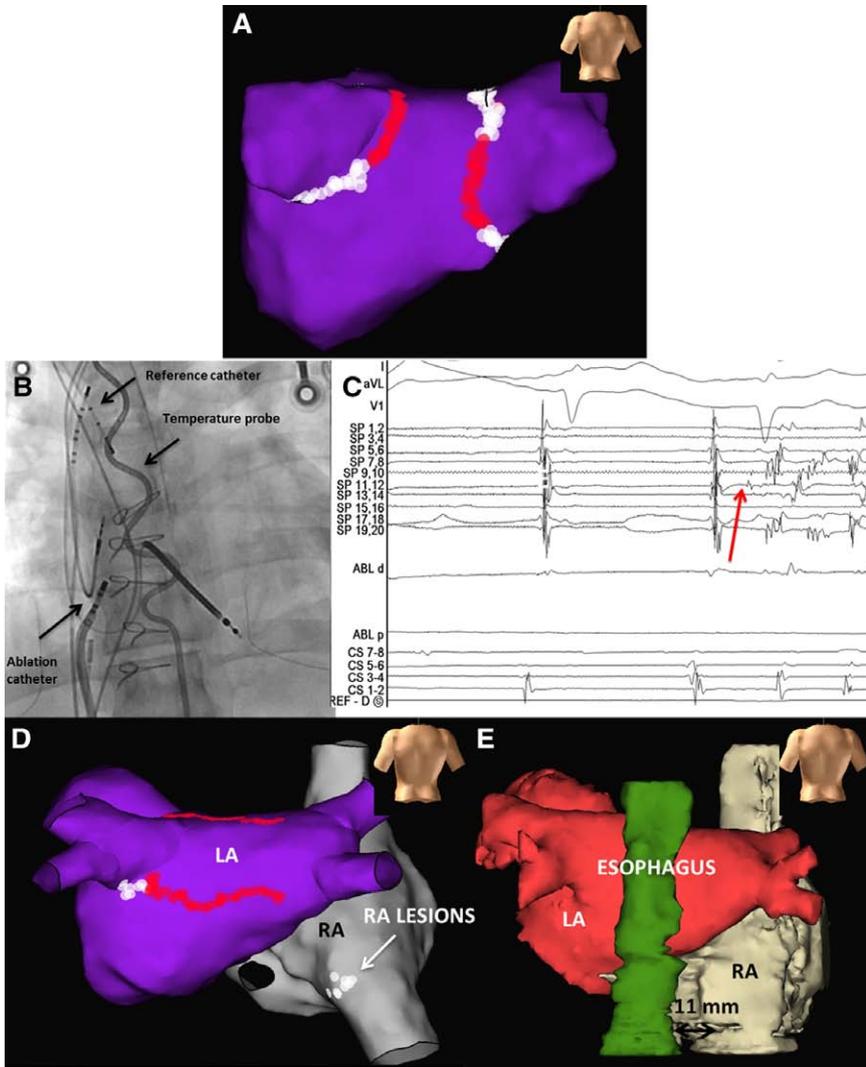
A, Initial pulmonary vein (PV) isolation with esophageal temperature rises (red lesions) seen on posterior wall. B, Fluoroscopic (anteroposterior) view of ablation catheter at site of triggering atrial premature complexes, with respect to the esophageal temperature probe. C, Intracardiac electrogram of atrial fibrillation trigger demonstrated on multipolar mapping catheter (spiral [SP] 11, 12). D, 3-Dimensional map of right atrium (RA), left atrium (LA), and ablation lesions (posterioranterior view). Extension of PV isolation with posterior wall isolation (esophageal temperature rise at red lesions). E, Relationships between RA, LA, and the esophagus (PA view) of CT reconstruction.
